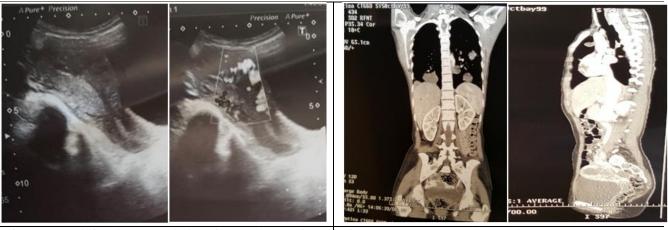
Pelvic ultrasound showing endometrium and parametrial vessels.
